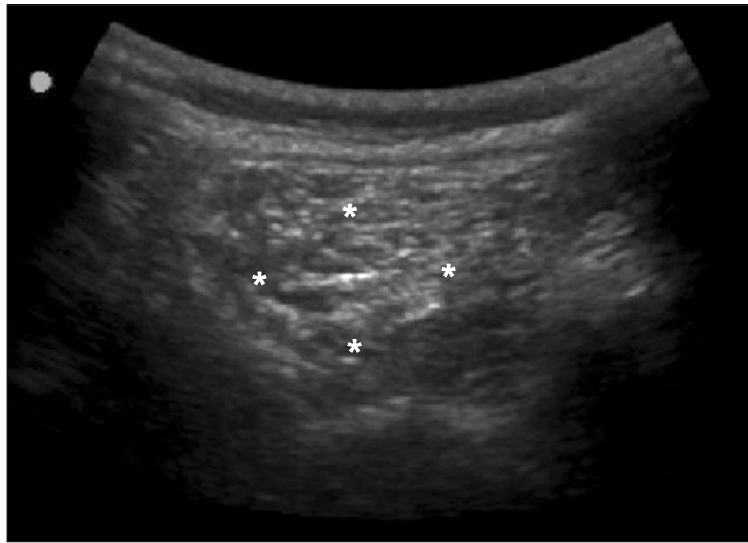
A hyperechoic pocket scanned at left gluteal area on ultrasound (asterix: hyperechoic mass).
